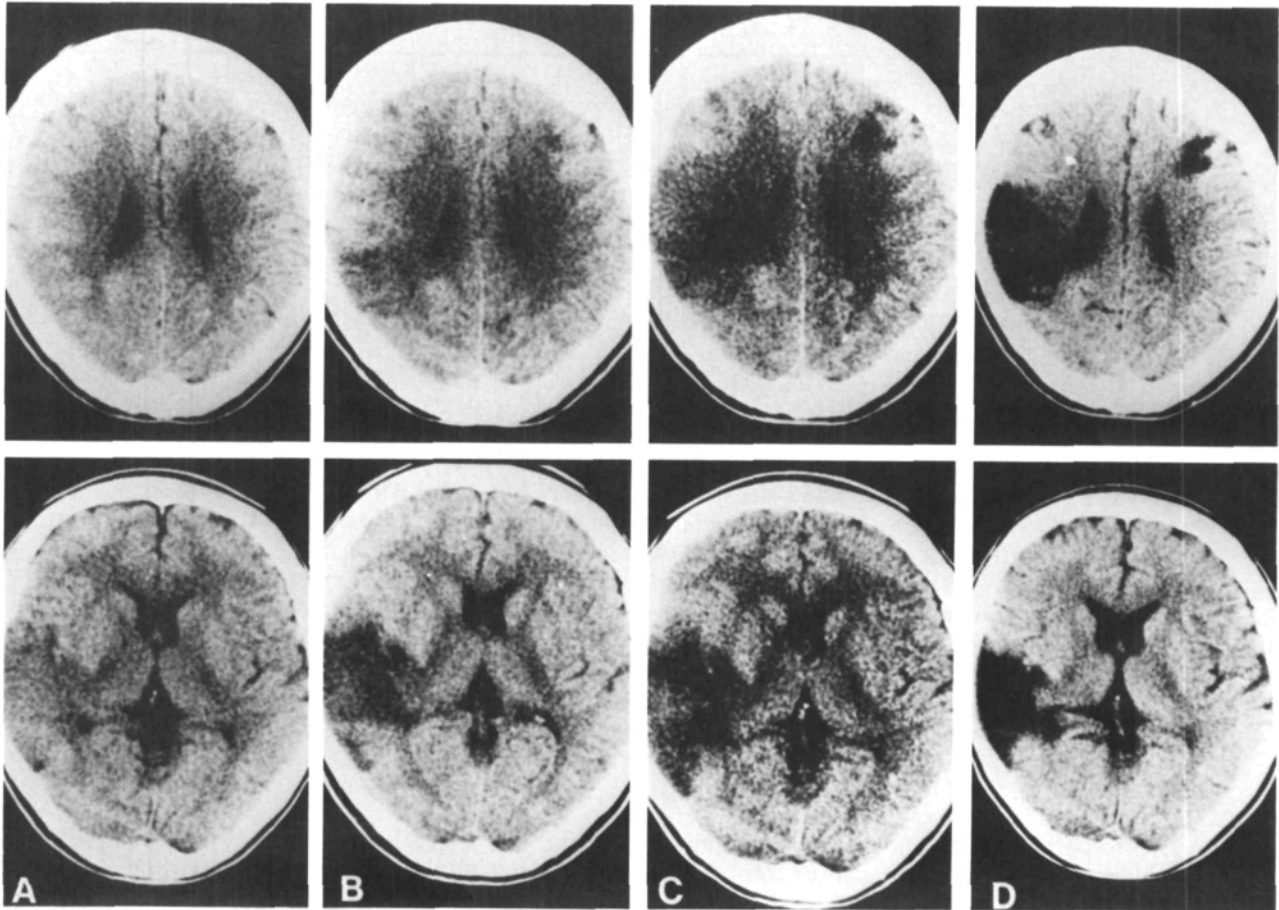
Cerebral computed tomograms showed low-density area in right temporal lobe on Day 1 (A). By Day 2, low-density area had extended to right parietal lobe (B). By Day 3, low-density area had appeared in left frontal lobe (C). On Day 54, clear low-density area remained in right parietotemporal and left frontal lobes (D).
